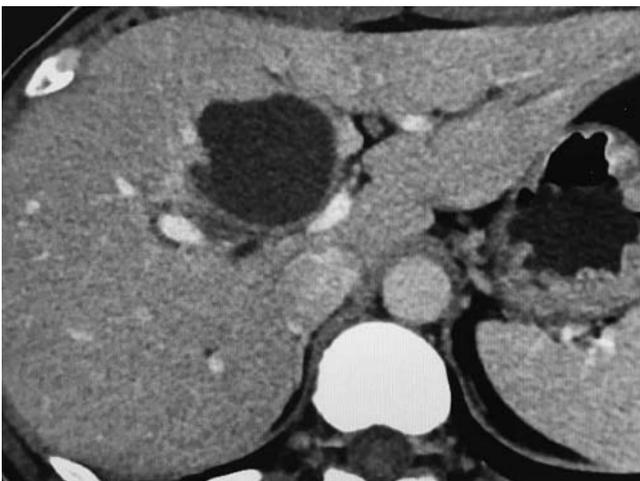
A computed tomography scan of the abdomen showed a cystic region including calcification and solid mass in segment 4 of the liver.
